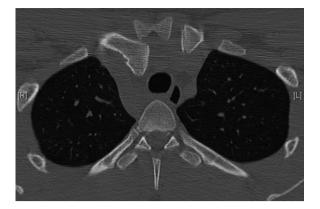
Axial CT demonstrates retrosternal dislocation of the right sternoclavicular joint.
